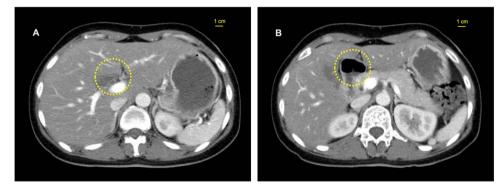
Contrast-enhanced computed domography (CT) scan of the trunk showing the disappearance of free gas detected in plain CT scan surrounding the porta hepatis (A) and the pyloric side of the stomach (B) with no signs of intestinal necrosis. The dotted circles show the area where the free gas disappeared.
